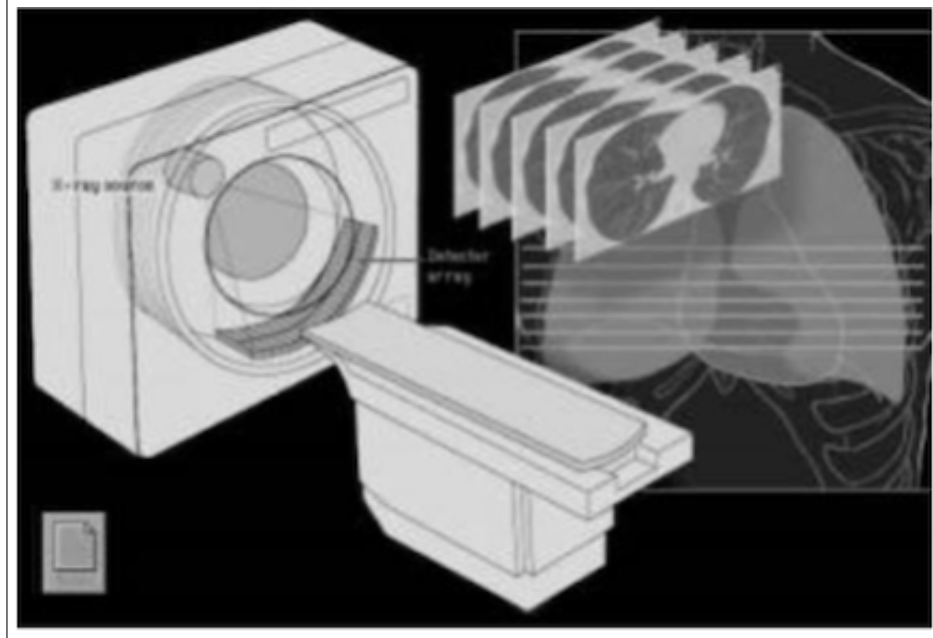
CT system and lungs image slices [15].
